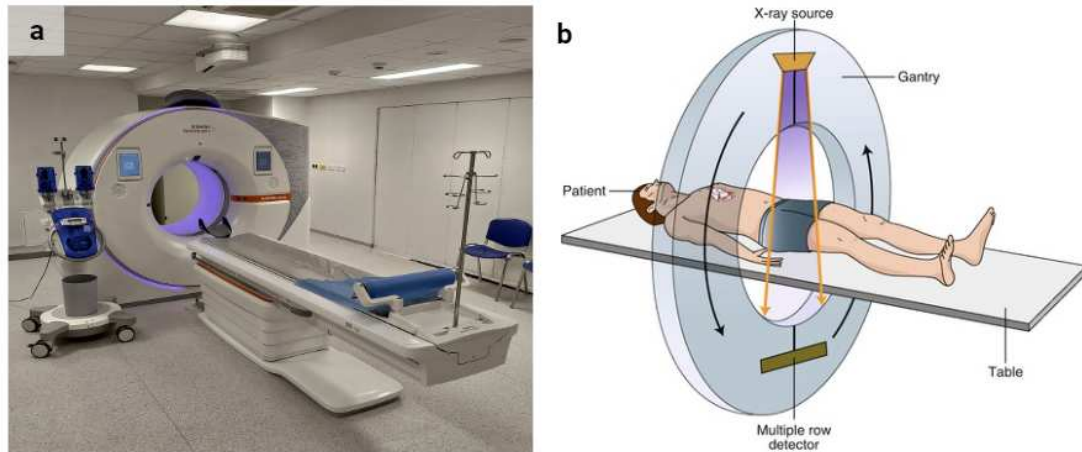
(a) Depiction of a modern CT scanner (Vendiš 2022), (b) main components of the CT scanner, including the gantry, the x-ray tube, the detector array, and the CT table (Garnett 2020).
